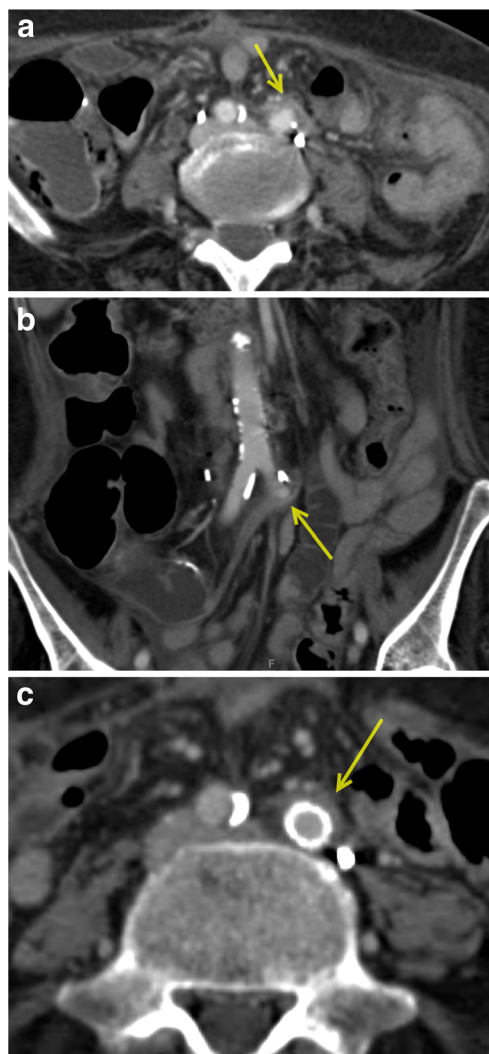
A patient with an ileal conduit and bright red hematuria underwent CT for further evaluation. a Transverse CT image showing a mildly dilated left ureter crossing the left common iliac artery (*arrow*) with effacement of the intervening fat plane. b Oblique coronal CT image showing an outpouching of the left common iliac artery where it is crossed by the ureter (*arrow*) which continues into the ileal conduit. c Transverse CT image after intervention showing a covered stent in the left common iliac artery and resolution of the arterial outpouching and ureteral dilation
